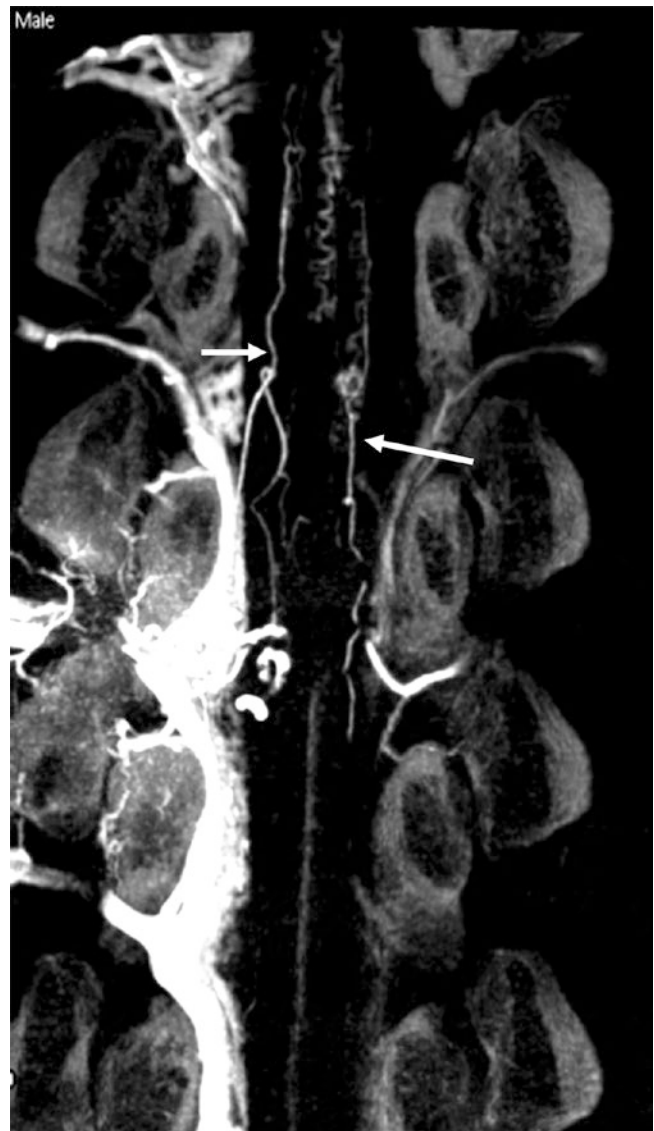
CBCT after complete elimination of the shunt. Note bilateral PSA were well-visualized on this plane (arrow)
